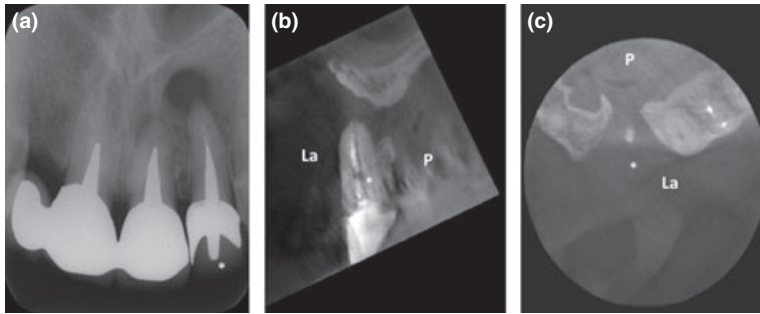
Type IV: A 'through and through' bone defect was observed around the apex of the maxillary left lateral incisor (*). (a) Periapical radiograph. (b) Labio-palatal slice image of the CBCT (3DX). (c) Horizontal slice image of the CBCT (3DX). La: labial side. P: palatal side.
